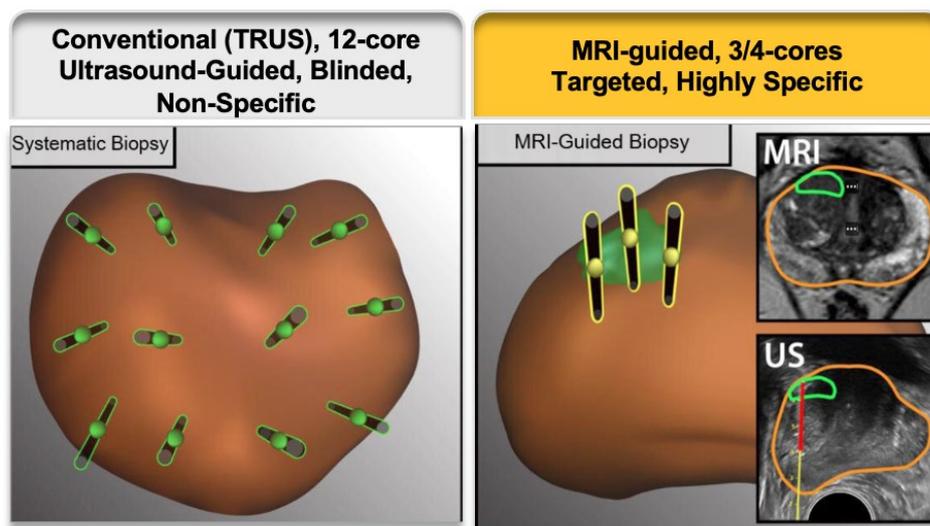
TRUS vs. MR/Ultrasound (US) FusionBiopsy
